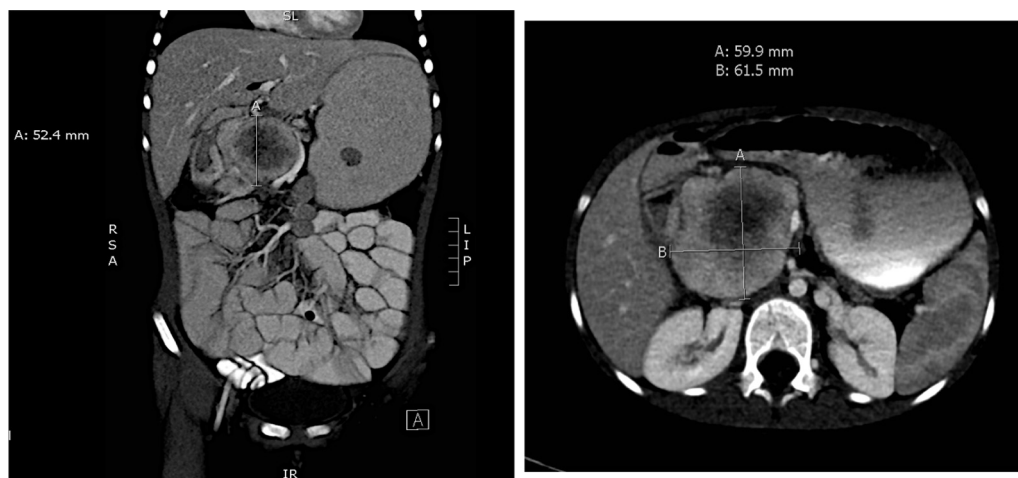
Coronal and axial computed tomography images demonstrating the head of pancreas mass measuring approximately 6 × 6 cm.
